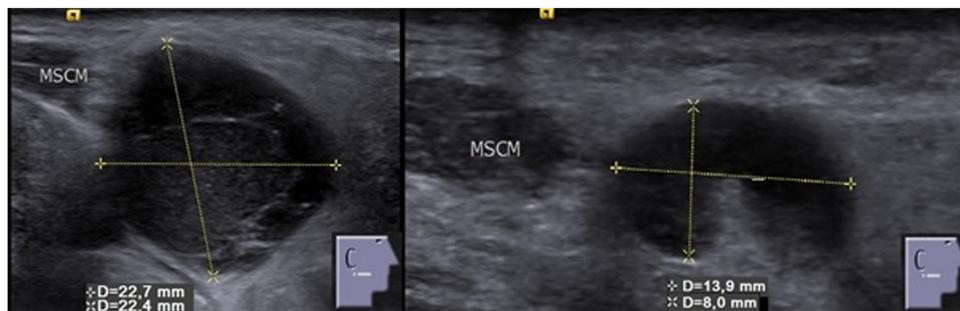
Left: Sonographic picture of a lesion in the right parotid gland 18 months after extracapsular dissection and verification of a cystadenolymphoma on the same side. Right: The same lesion, 14 months later, with a large reduction in growth (MSCM: sternocleidomastoid muscle).
